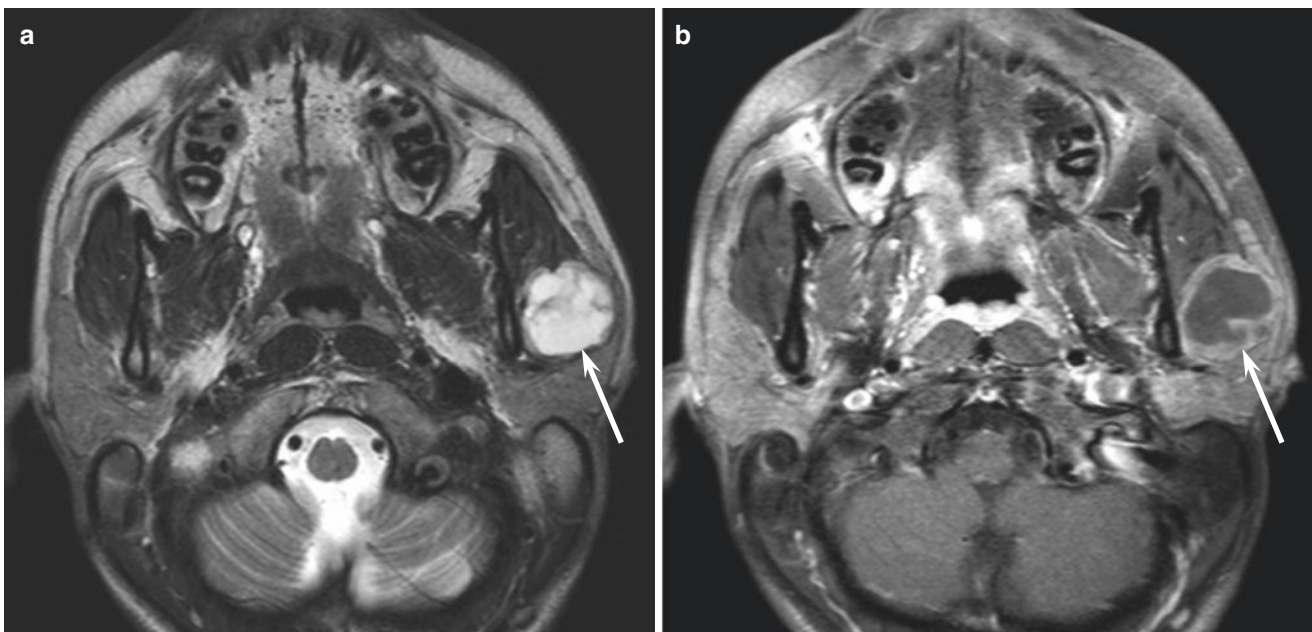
A 19-year-old man with acinic cell carcinoma of the left parotid gland. (a) T2-weighted image shows a predominantly cystic lesion (arrow). (b) Fat-suppressed gadolinium-enhanced T1-weighted image shows a well-demarcated lesion (arrow) with extensive unenhanced areas
